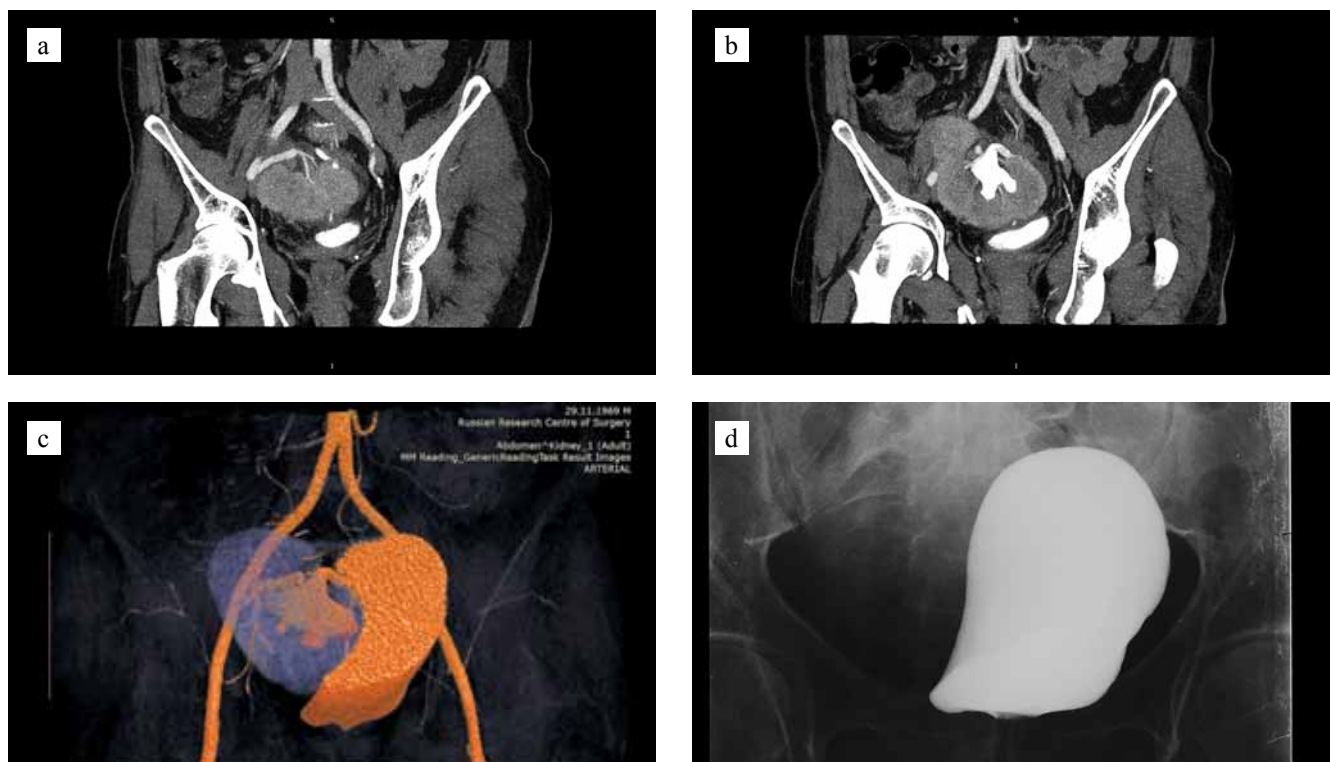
X-ray diagnostic examination: a, b – computed tomography scans of arterial and uro phase; c – 3d-reconstruction; d – retrograde cystography
